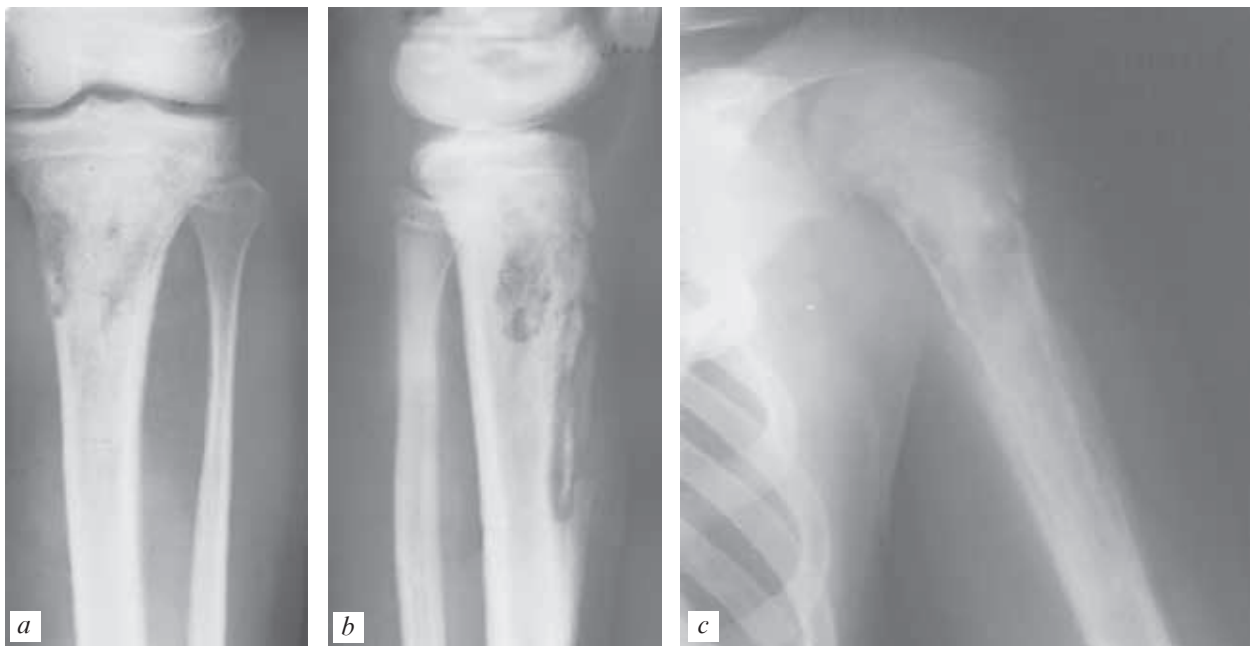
X-ray at chronic osteomyelitis (a-c)
